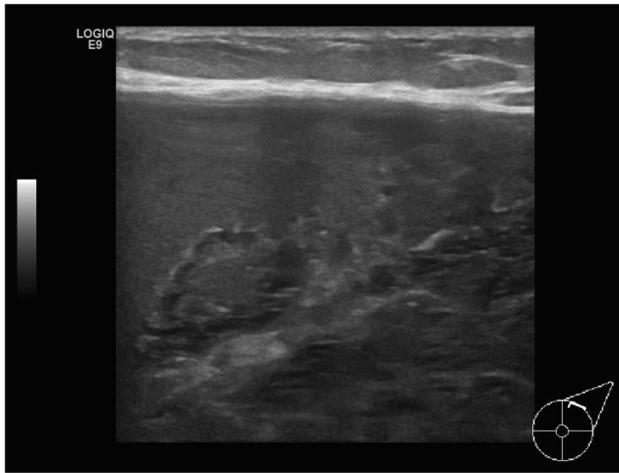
Ultrasound image of the left breast showing a heterogeneous turbid liquid collection with interspersed hyperechoic gelatinous material and anechoic cystic-fluid collections scattered through inhomogeneous lacunar fibroglandular tissue
